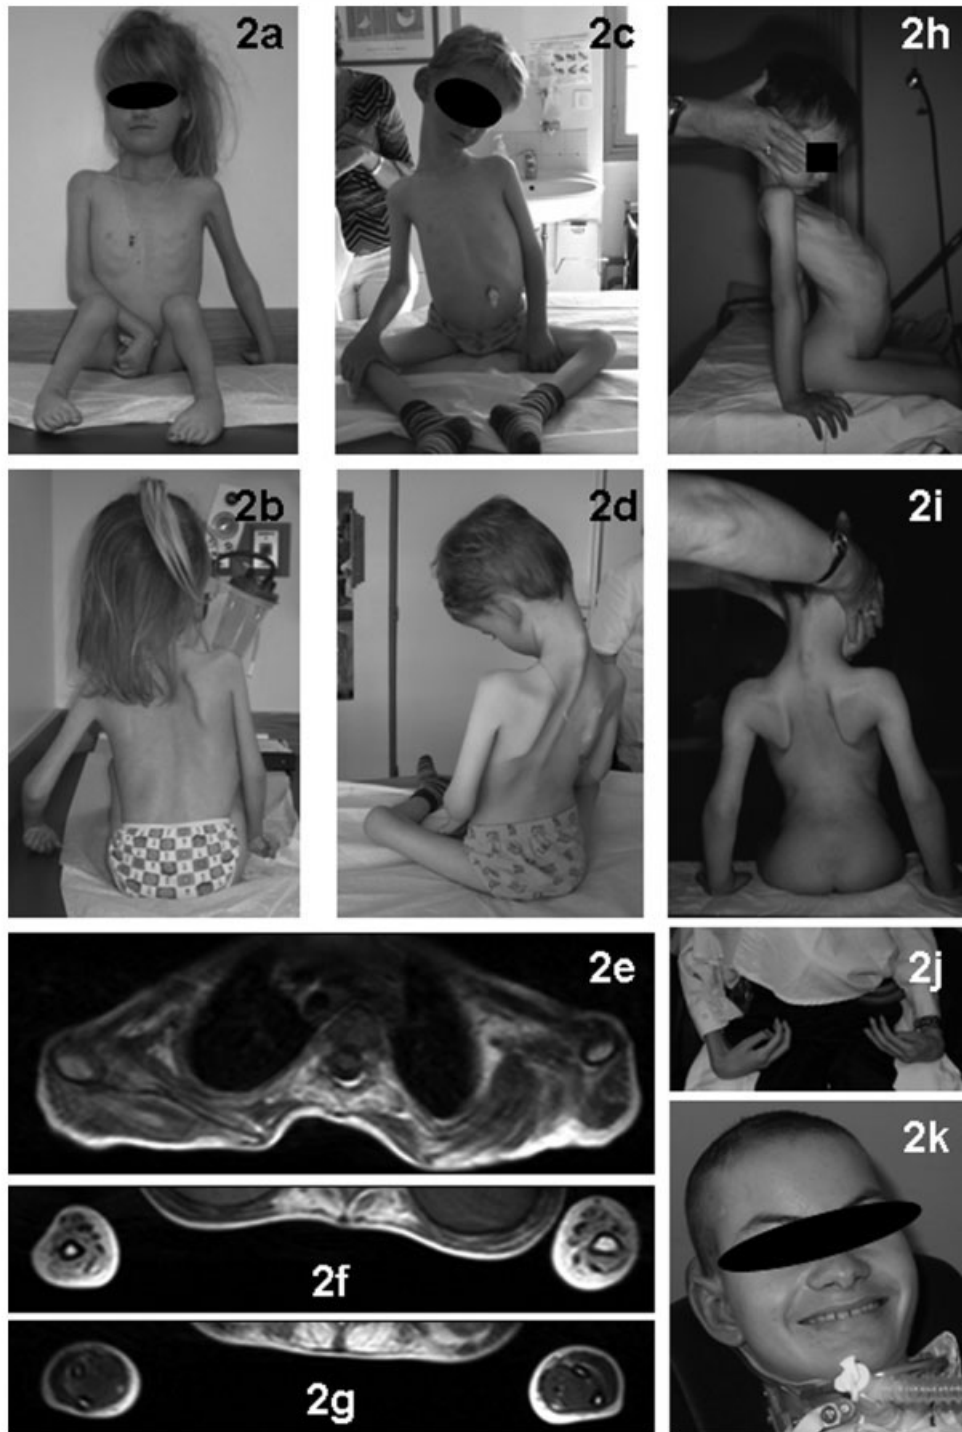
Patients 4 (A, B), 14 (C–G), and 15 (H–J) with “dropped-head” LMNA-related congenital muscular dystrophy (L-CMD). Note the striking neck involvement, the typical phenotype with spinal thoracolumbar lordosis, scapulohumeral wasting, and contractures in hands, feet, knees, and hips, in the absence of elbow contractures. Muscular magnetic resonance imaging of the scapular region and upper limbs (T1 sequences) showing severe abnormal signal in the biceps, triceps, and thoracic paraspinal muscles, moderate involvement of deltoid, and sparing of the distal arm muscles (E–G). Note the typical axial-cervical involvement with severe weakness and spinal hyperextension, and the diffuse wasting of limbs with relative preservation of distal arms at early stages. In the second decade of the life, there is severe diffuse weakness and contractures (D) in a tracheotomized patient with sparing of facial muscles (E). Note the striking neck involvement, the typical phenotype with spinal thoracolumbar lordosis, scapulohumeral wasting, and contractures in hands, feet, knees, and hips, in the absence of elbow contractures. Muscular magnetic resonance imaging of the scapular region and upper limbs (T1 sequences) showing severe abnormal signal in the biceps, triceps, and thoracic paraspinal muscles, moderate involvement of deltoid, and sparing of the distal arm muscles (E–G). Note the typical axial-cervical involvement with severe weakness and spinal hyperextension, and the diffuse wasting of limbs with relative preservation of distal arms at early stages. In the second decade of the life, there is severe diffuse weakness and contractures (J) in a tracheotomized patient with sparing of facial muscles (K).
